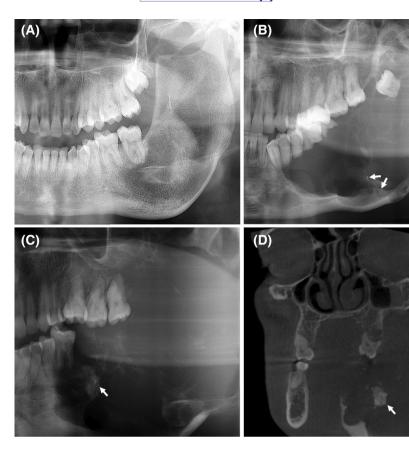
(A) Ameloblastoma with a fibro-osseous-like or mixed-density appearance involving the left mandibular corpus and ramus-complex. (B) AB with fine specks of internal calcifications (arrows) and a coincidental finding of a compound odontoma apical of the left maxillary incisors. (C) Cropped PR and (D) coronal CBCT image showing an AB with a larger conglomerate of internal calcifications (arrows). AB, ameloblastoma; CBCT, cone-beam computerised tomography; PR, panoramic.
